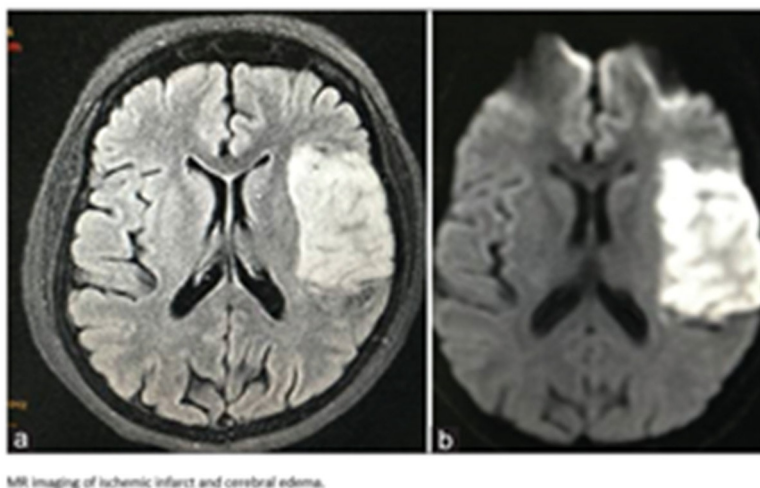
Example of MRI DWI of ischemic infarct and cerebral edema
